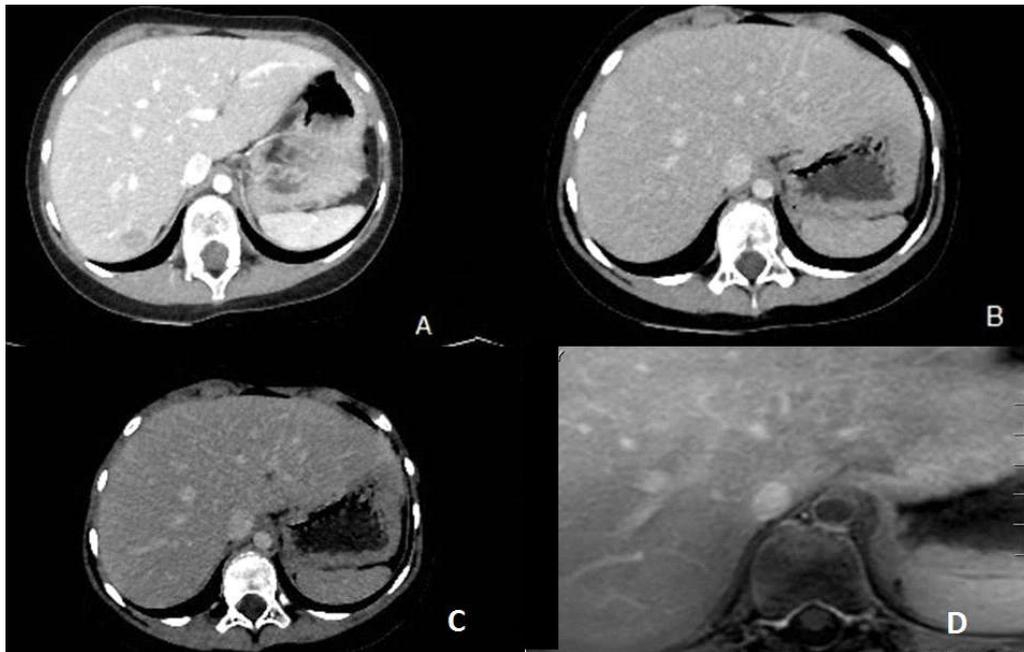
A-B-C abdominal CT axial scan images : on CT images lesion regenerative nodule appears hypoattenuating and it remains isodense in both arterial and portal venous phased. D: abdominal MRI axial images (THRIVE after contrast agent injection) the nodule presents enhanced similar to normal liver parenchima on delayed image
